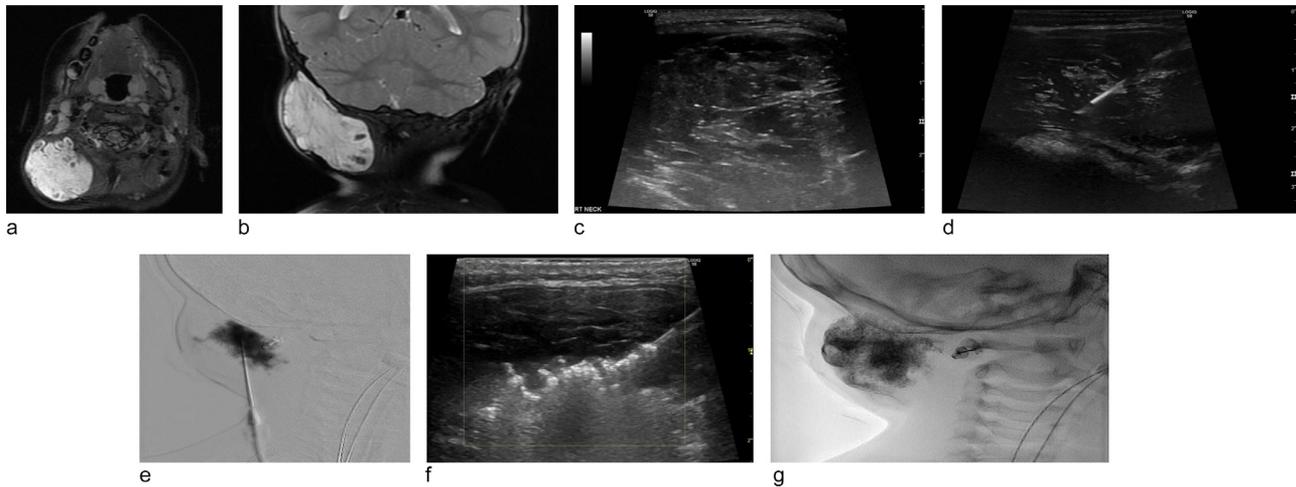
3-year-old female with VM of the right neck. Sclerotherapy was performed with STS foam. Axial STIR (a) and coronal T2 (b) magnetic resonance images of the right neck show lobular increased signal of the VM with scattered hypointense foci compatible with phleboliths. Grayscale ultrasound demonstrates dilated venous channels within the malformation (c) and ultrasound-guided placement of a 21-gauge EchoTip needle into one of these channels (d). Intralesional venography using negative roadmap fluoroscopy (e) shows opacification of a portion of the VM without evidence of extravasation or visualization of large draining veins. Grayscale ultrasound shows echogenic foam being injected into the malformation (f). Postsclerotherapy spot fluoroscopic image (g) demonstrates contrast opacification of the treated lesion.
